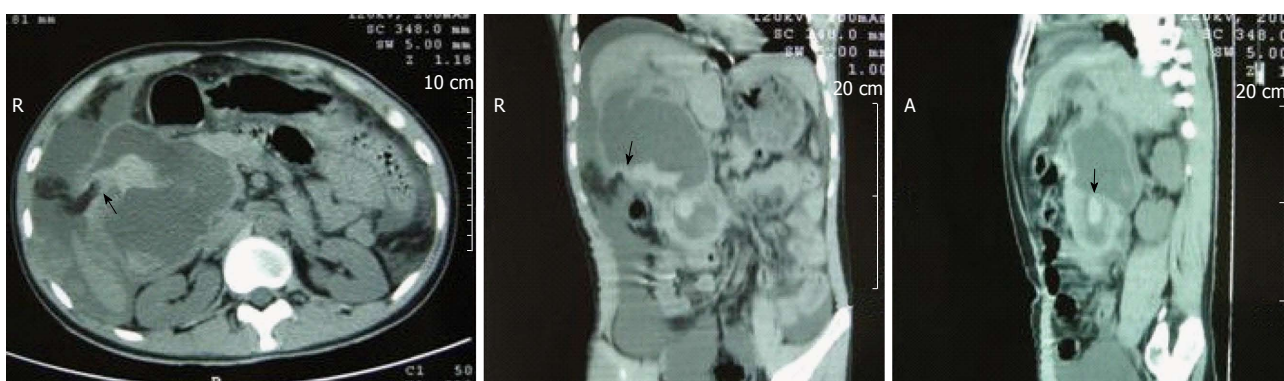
Abdominal computed tomography shows a rupture in the right wall of the choledochal cyst with hemorrhage (arrow).
